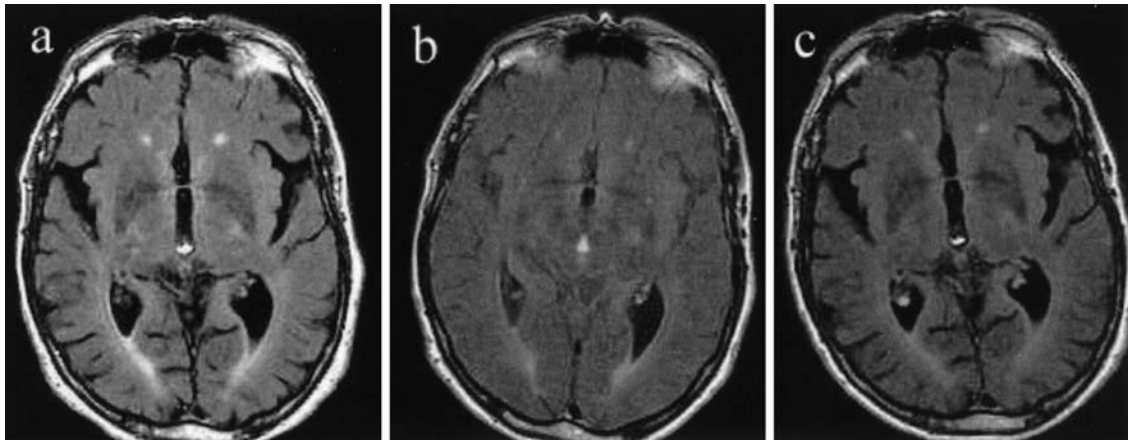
a Fast fluid-attenuated inversion recovery (FLAIR) performed in a patient with an ischemic stroke 4 days after the clinical onset of symptoms (the lesion is not shown in this slice). b In the follow-up MRI performed with the same sequence 2 h later, cerebrospinal fluid (CSF) signal is diffusely increased in subarachnoid spaces with consequent lesser contrast between brain cortex and CSF itself. c The CSF signal returned to normal value 2 days later
